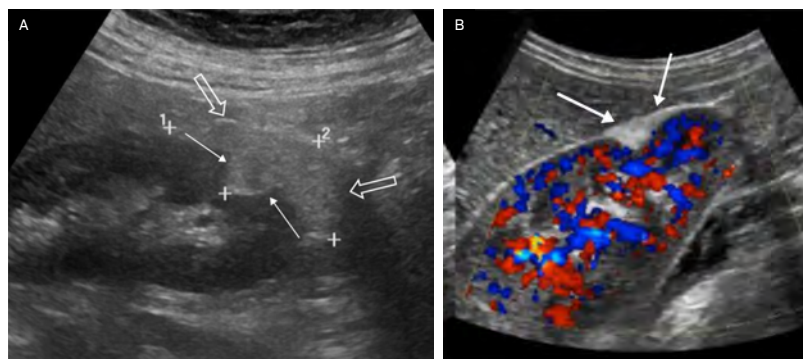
Renal US in an elderly patient with a large angiomyolipoma (AML) demonstrating an angular interface (solid arrows), but in addition the AML overflows the margins of the kidney as the “overflowing beer” sign (open arrows) (A). Renal color Doppler US image in an adult with peripheral AML demonstrating the “overflowing beer” sign (arrows) of the echogenic AML (B).
